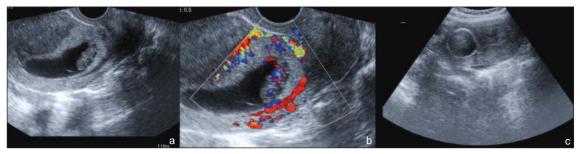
The initial and the post treatment ultrasonic views of the 6th case; a) The placenta was seen on the lower segment of the uterus, b) Increased vascularization on the placentation site, c) The tamponade inserted in the cavity was seen tamponading the scar region.
